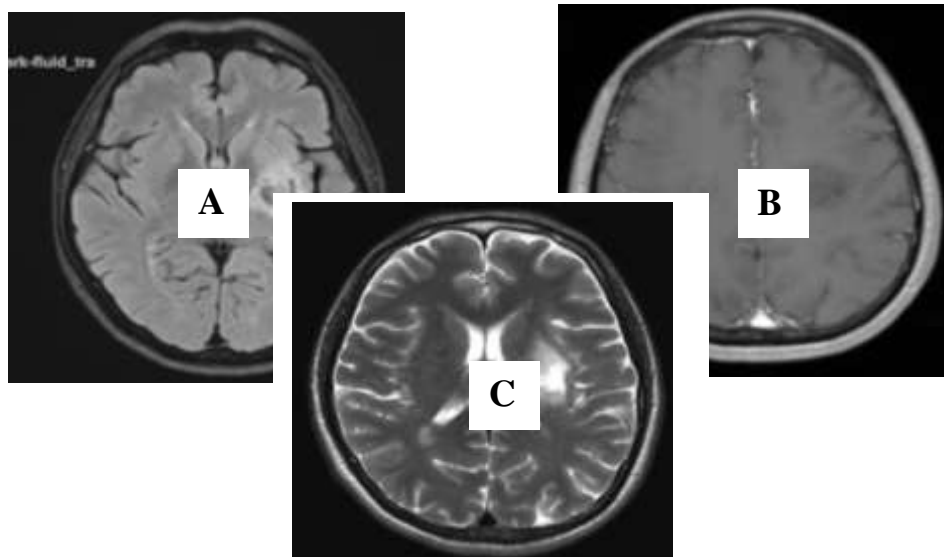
Head MRI with contrast: A. FLAIR, has shown iso-hypointense lesion; B. T1WI, has shown hypointense lesion; C. T2WI, has shown hyperintense lesion
